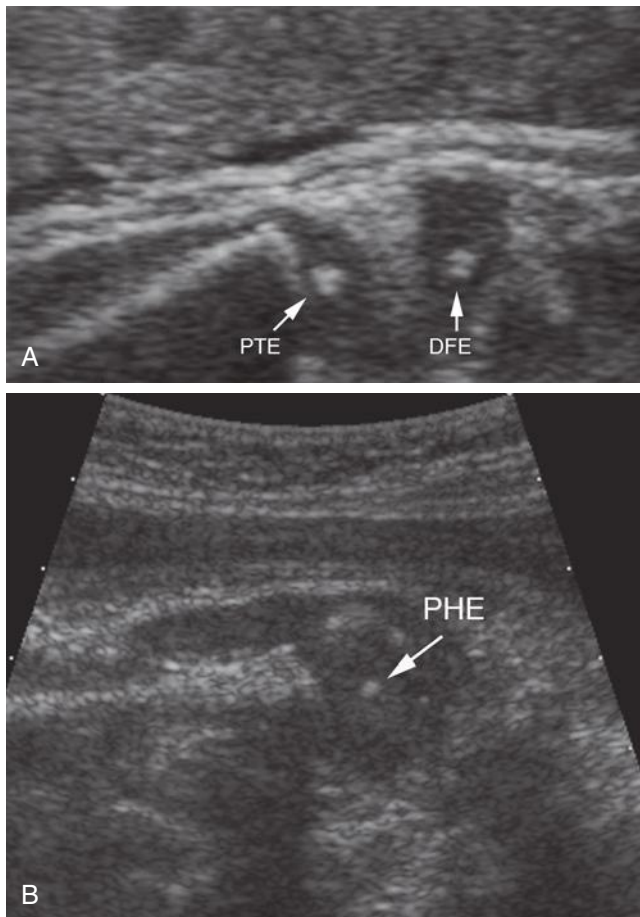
A, Sonogram of the knee in a fetus at 35 weeks' gestation. Increased echogenicity from the secondary ossification centers of distal femoral (DFE) and proximal tibial (PTE) epiphyses are seen. B, Sonogram of the proximal humerus in a fetus at 38 weeks' gestation. Ossification of the proximal humeral epiphysal ossification center (PHE) is noted.
